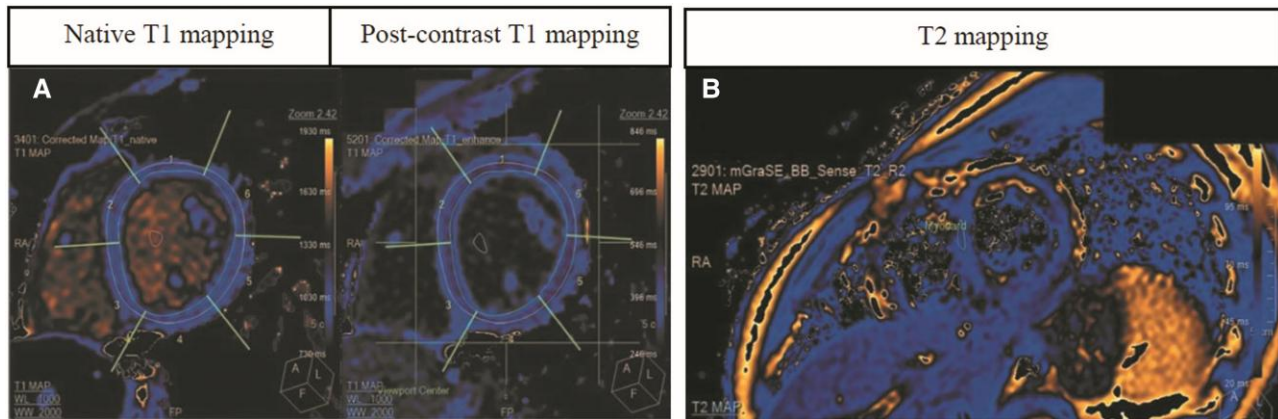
(A) Native T1 mapping and postcontrast images showing a region of interest (ROI) draw in the six basal segments with increased T1 native in all segments (1031 ± 23.7 ms) and postcontrast T1 mapping (469 ± 20.3 ms), and (B) T2 mapping image with value (54.1 ± 2.96 ms). Data are reported as mean \pm SD (range). Cutoff value⁹: T1 native > 1000 ms, T2 native > 55.9 ms. The normal values at our centre: native T1 mapping = 998 ± 23.9 ms, enhanced T1 mapping = 420 ± 9 ms, T2 mapping = 54.6 ± 8.64 ms. ms, milliseconds. Cardiac magnetic resonance (CMR) acquisition protocol included balanced steady-state free precession cine-MR (SSFP cine MR) images. Oedema CMR was performed by black-blood T2-weighted short tau inversion recovery (STIR) and T2 mapping. A dose of 0.2 mmol/kg Gadobutrol (Gd-DO3A-butrol, Gadovist; Bayer Healthcare, Leverkusen, Germany) was injected with a rate of 2.5 mL/s.
